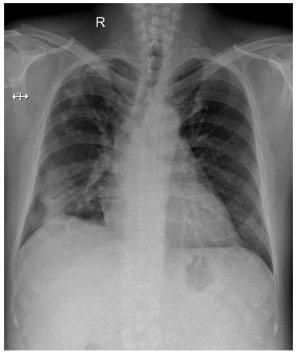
Chest X-ray obtained 3 days after corticoid initiation.
